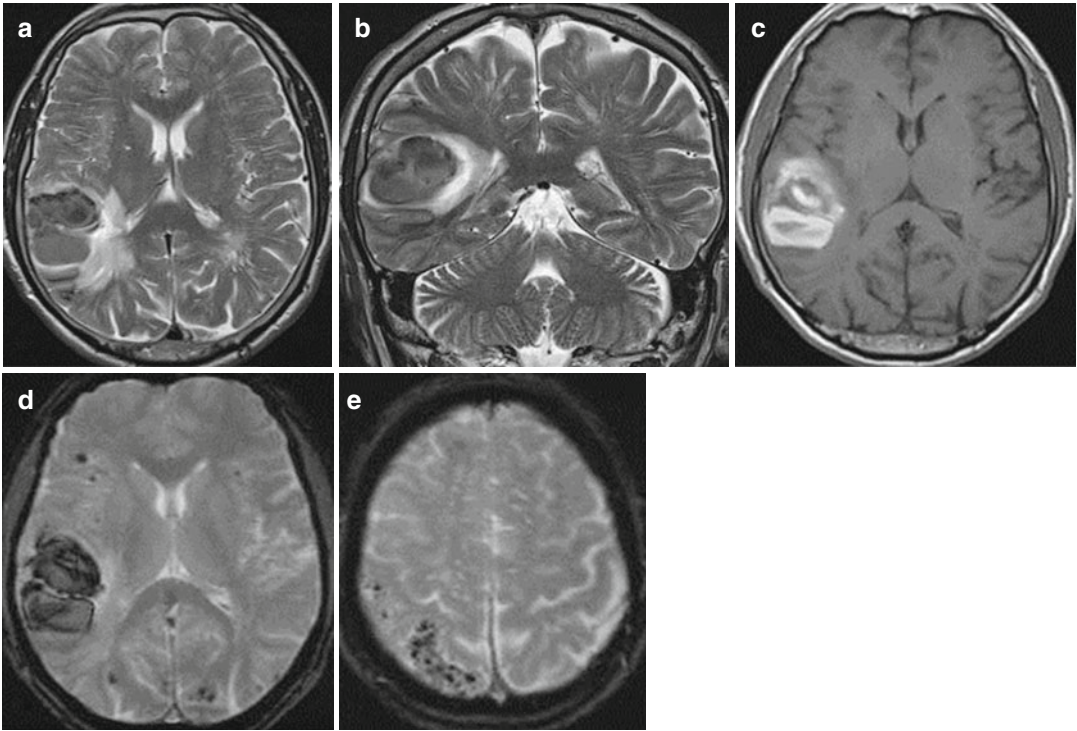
Intracranial hemorrhage in cerebral amyloid angiopathy. Axial and coronal T2- and axial T1-weighted images (a–c) demonstrate a large right intracranial
